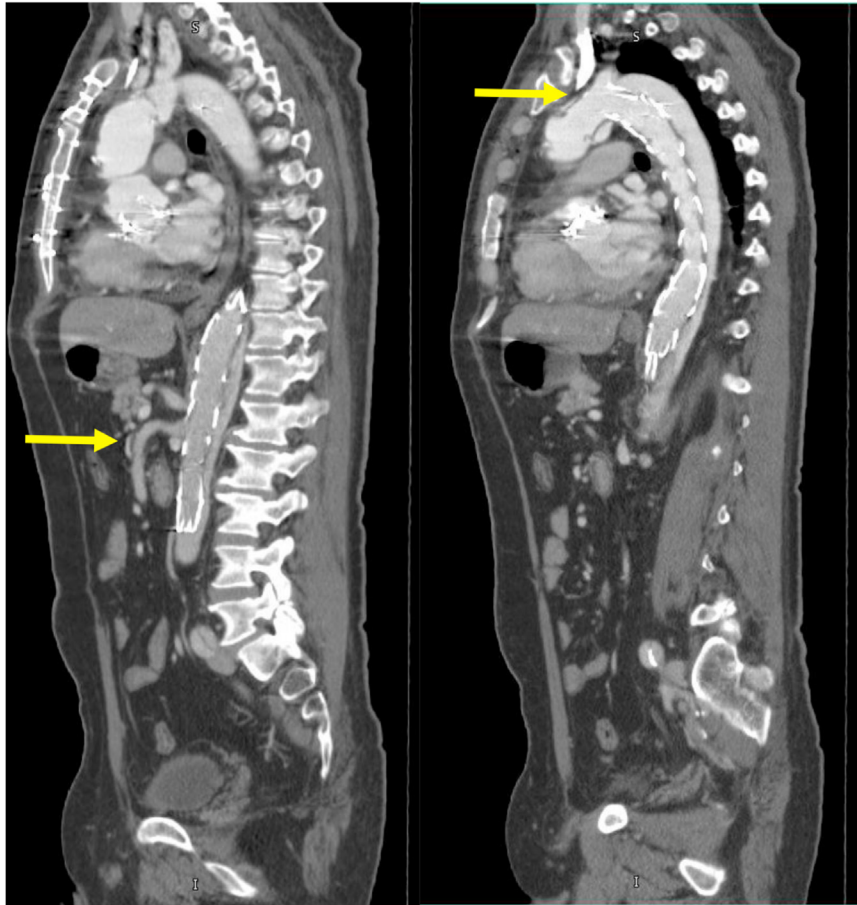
Computed tomography angiography at 1 month postoperatively showing perfusion of visceral vessels (*arrow; Left*) and origin of endovascular graft distal to left subclavian artery (*arrow*) after the proximal bare metal stent was removed during definitive open repair (Right).
